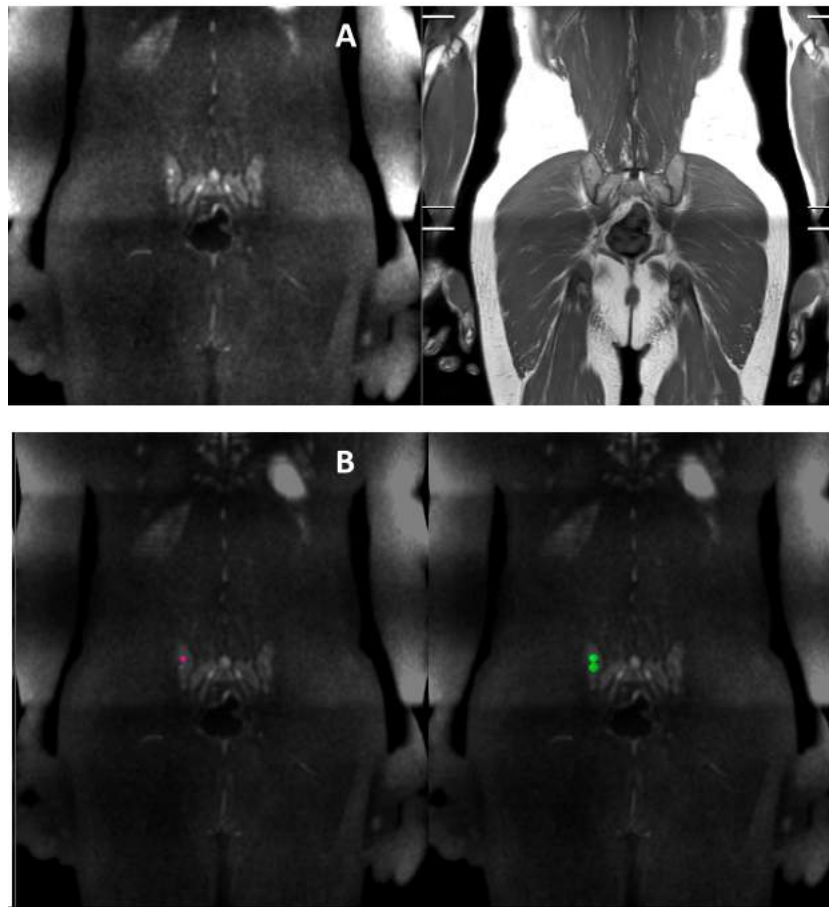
Possible lesion on the iliac bone segmented by E3 (red) and E4 (green) on Case 8 (male). A- representative coronal slice is zoomed to fit the iliac bone on DWI (left) and T1w (right). There are spotted two bright points on DWI that are coherent with dark points on T1w. B- manual segmentation of E3 and E4.
